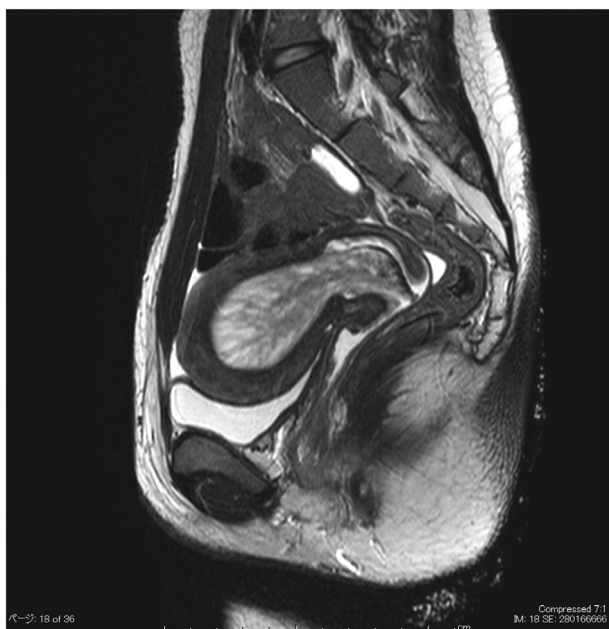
Pelvic MRI(T2-weighted sagittal image) shows that myometrial invasion did not occur in the uterus.
